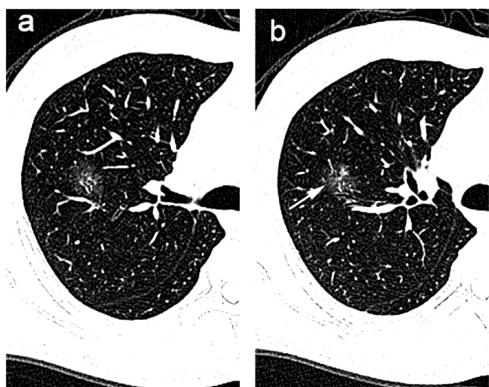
CT characteristics of a 46-year-old male patient. AAH of the segmental alveolar epithelium in the upper lobe of the right lung, with focal area reaching AIS. (a) CT plain scan showed the ground glass density of the lesion. The size was 29.6×24.1 mm, the margin was irregular and the air bronchogram sign was seen in the lesion. (b) Adjacent blood vessels shift and enter the interior of the lesion, which is known as the tumor vascular sign (arrow). AAH, atypical adenomatous hyperplasia; AIS, adenocarcinoma in situ.
